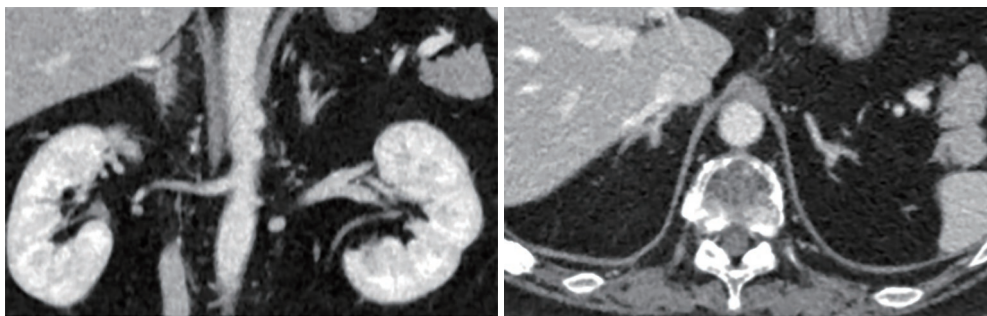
Abdominal CT. Suspicious small nodular shadow on the external branch of the left adrenal gland, while enhancement scan found no overt abnormal enhancement.
